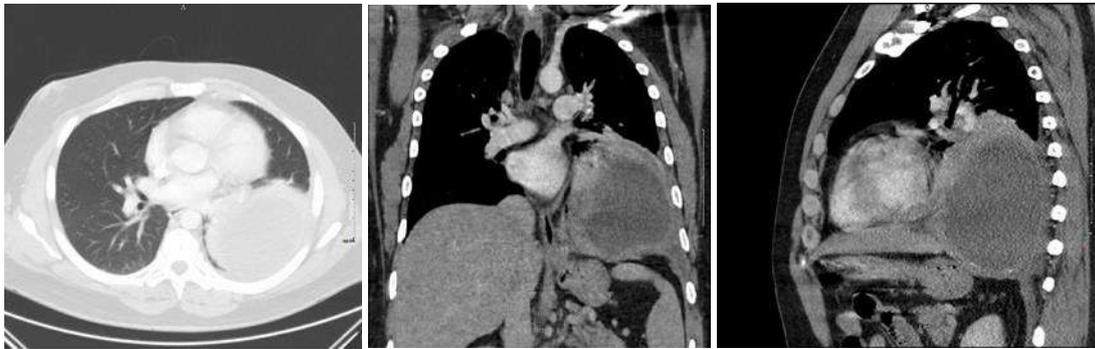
A 2B and 2C: Admission chest CT transverse, coronal and sagittal views – Note the oval and very well circumscribed cystic lesion measuring 14.1 x 11.5 x 13.2 cm within the left lung parenchyma with minimal pleural effusion present at the base.
